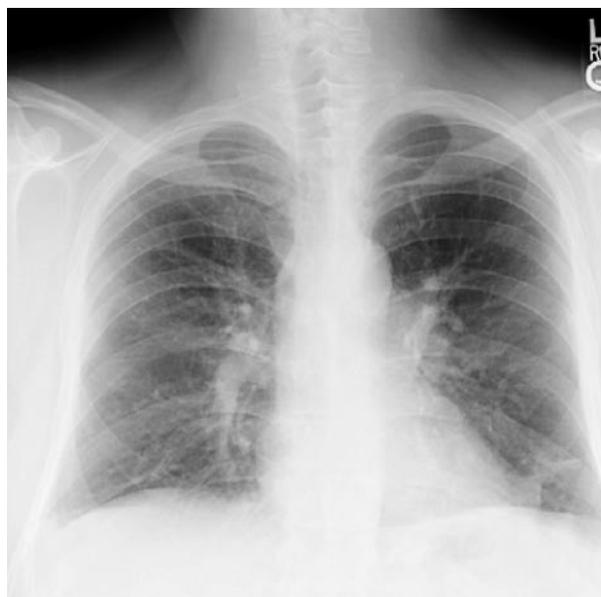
Chest radiograph of the case patient at discharge showing minimal residual left lower lobe opacity.
